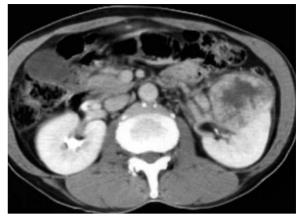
Collecting duct carcinoma in a 65-year-old man. Axial contrast-enhanced CT scan shows the left kidney tumor appears exophytic as collecting duct carcinoma enlarges.
